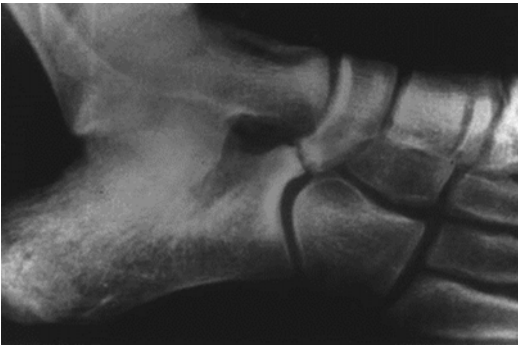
Calcaneonavicular bar shown on an oblique radiograph of the foot
